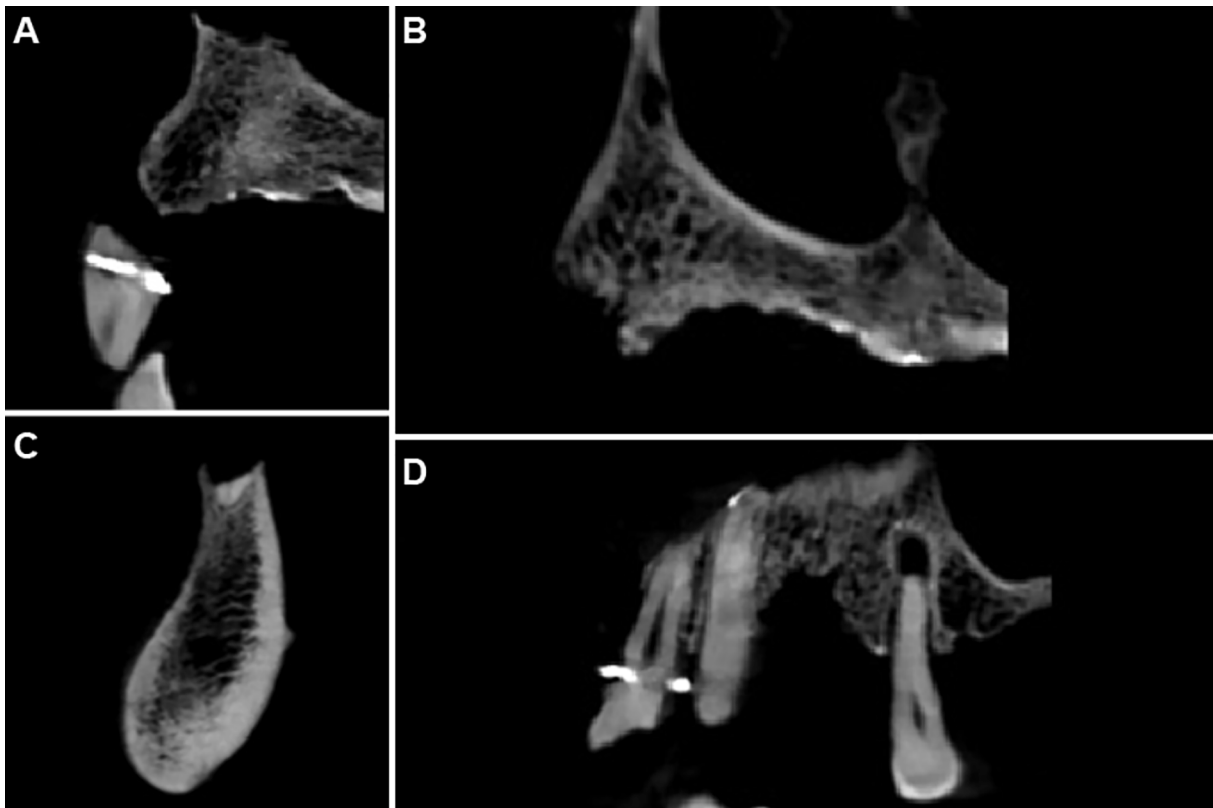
3D CBCT imaging analysis. A: Left upper central incisor (tooth 21); B and D: Left upper first premolar (tooth 24), absence of cortical bone; C: Left lower central incisor (tooth 31) apex in the alveolus, showing a post-mortem fracture.
